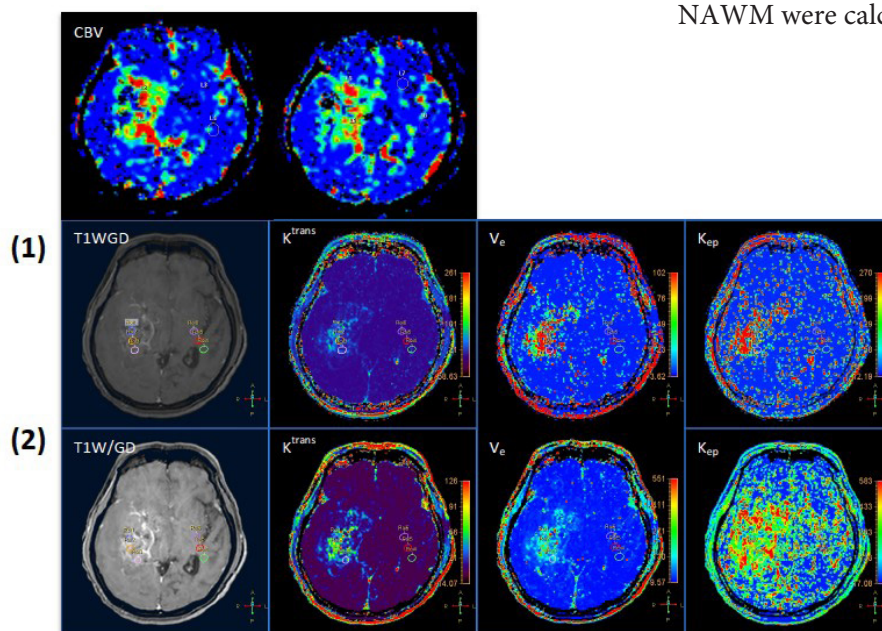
A 43-year-old male with pathologically proven glioblastoma with oligodendroglial component WHO 2007 grade IV. Images demonstrate ROIs in enhancing areas of tumor and contralateral NAWM. a. CBV map from DSC-MRI and parameter maps from DCE-MRI with (1) 30 and (2) 70 dynamic acquisitions
